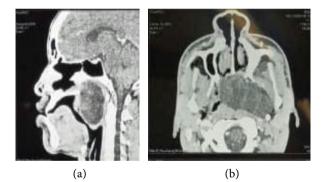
Sagittal (a) and frontal (b) CT images showing the mixed density mass in the nasopharynx.
